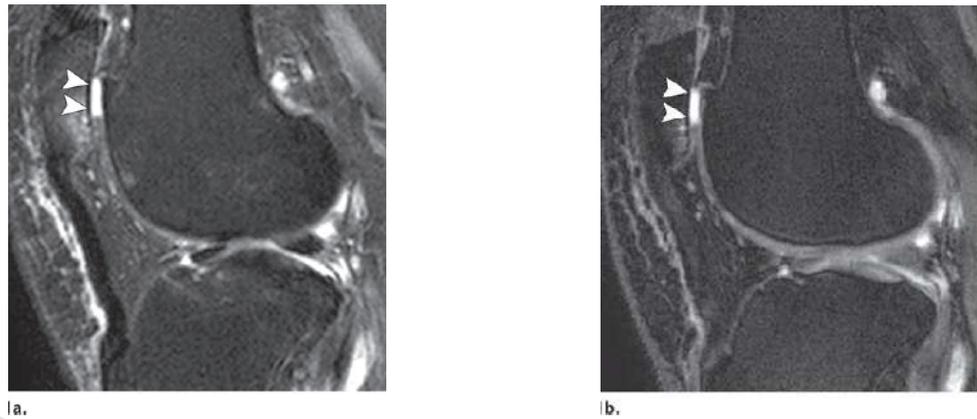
Sagittal T2-weighted fat-suppressed fast SE image (a) and water excitation DESS image obtained with a flip angle of 90° (b) both accurately depict a full-thickness cartilaginous defect (arrowheads) at the patella in another patient.⁽⁵²⁾
